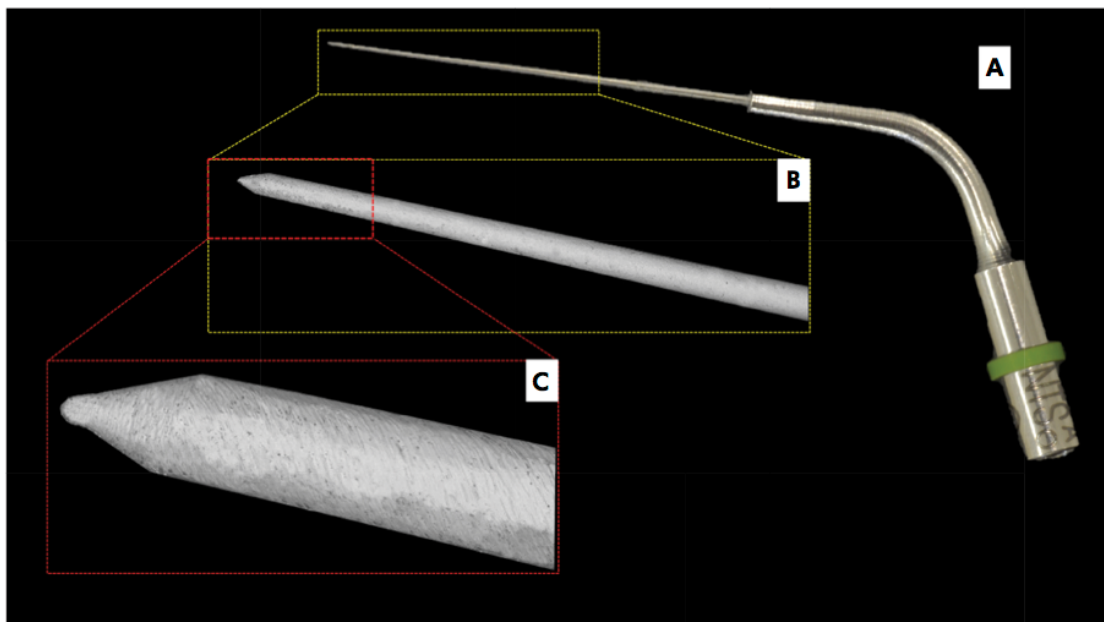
The ultrasonic nickel-titanium tip NiTiSonic® (A); SEM images at 30x magnification (B) and at 150x (C), evidencing the smooth surface and the noncutting tip.
